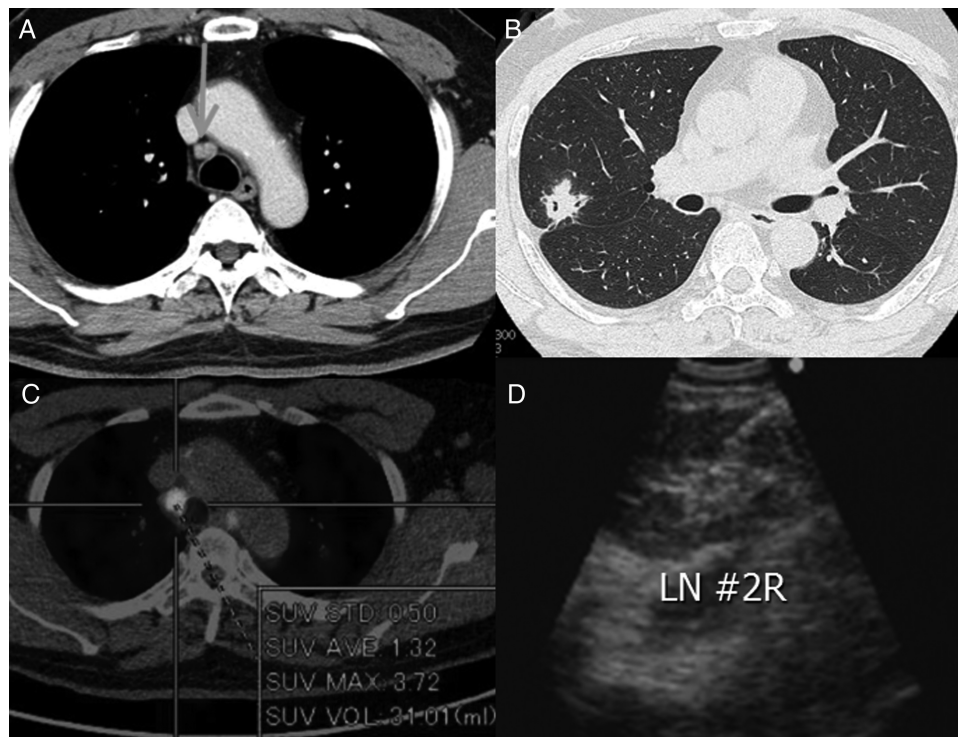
A 58-year-old male patient with lung cancer in the right middle lobe had mediastinal lymph node enlargement on computed tomography (CT) (A and B), positron emission tomography/computed tomography (PET/CT) (C) and endobronchial ultrasound (D) imaging.
